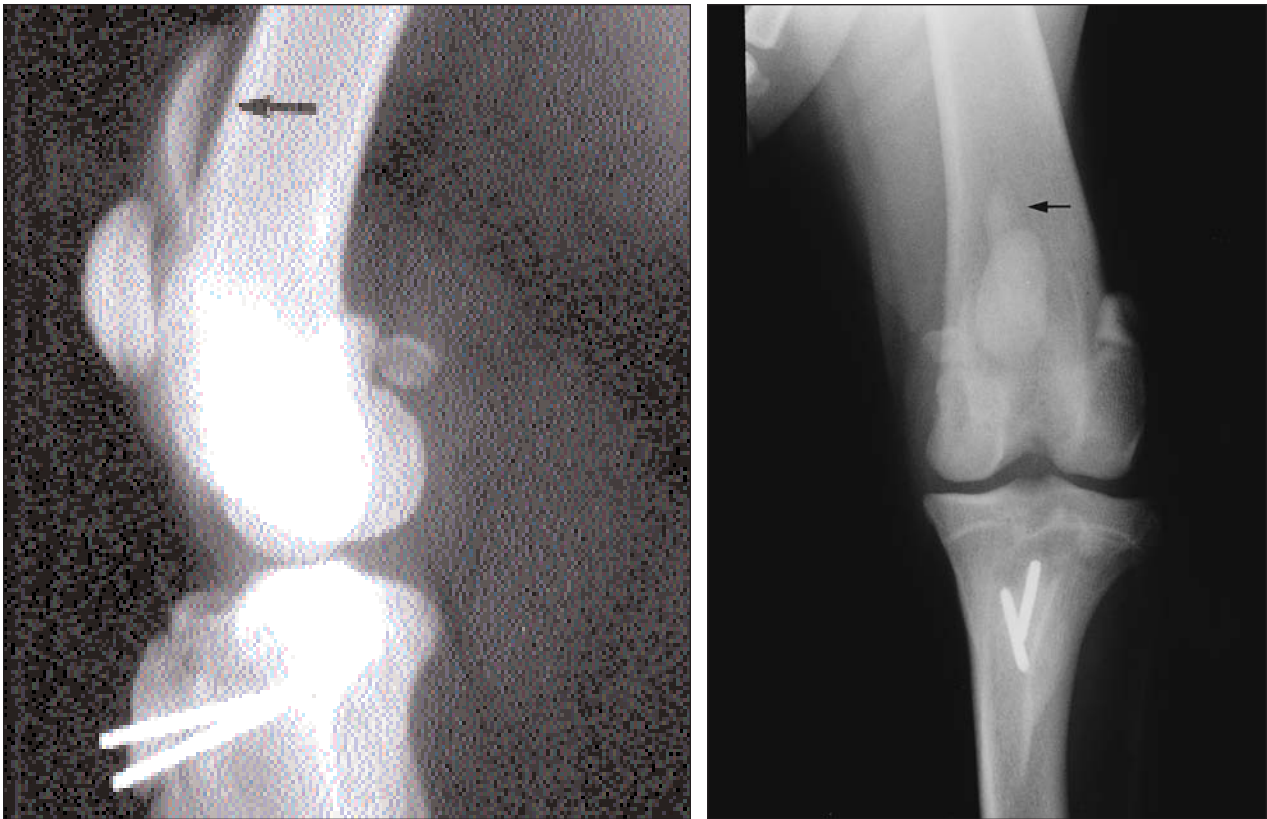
Same radiographic views as in Figure 1. Notice the displaced wedge-shaped bone fragment (arrows) proximal to the patella.
